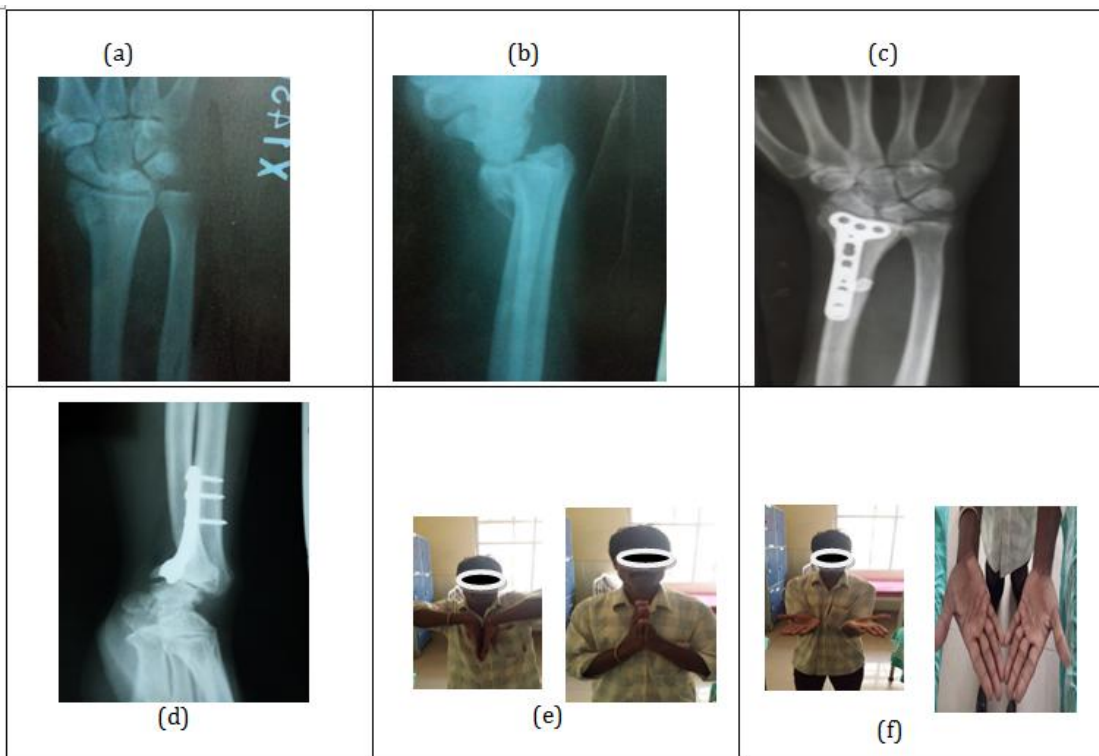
of patient with excellent result: (a, b)-preop X-ray. (c, d)- final follow up Xray. (e, f)- Clinical Photos
